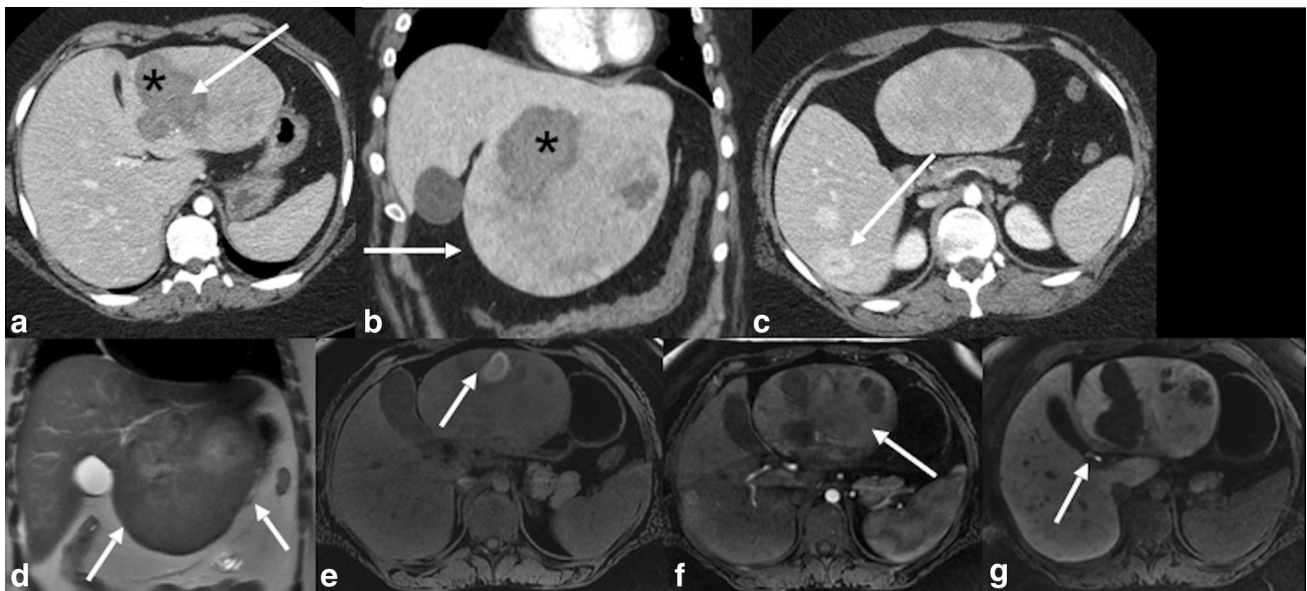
A 21-year-old woman with history of OCP use who presented with acute abdominal pain. a Axial and b Coronal CT images demonstrate a large, exophytic heterogeneous hepatic mass (arrows). The mass is isoenhancing to the liver, suggestive of an adenoma, given the risk factors. Areas of non-enhancement (asterisk) are suspicious for hemorrhage. c Additional numerous hyperenhancing masses (arrows) were present, raising suspicion for adenomatosis. MR imaging was recommended for follow-up. Follow-up MR imaging was performed. d Coronal T2-weighted image demonstrates a heterogeneous exophytic mass (arrows). e T1-weighted image
